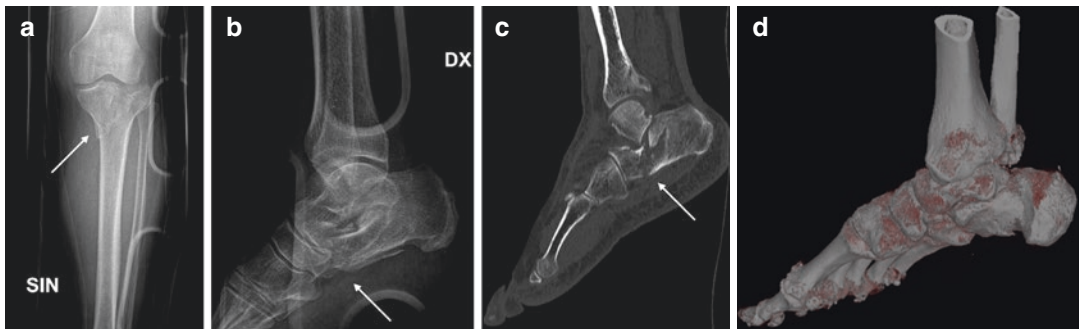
Plain film views (a, b), CT in sagittal plane (c), and volume rendering CT (d) of a proximal tibia (a, arrow) and astragalo-calcaneal fractures (b, c, arrows and d) due to a fall from height
